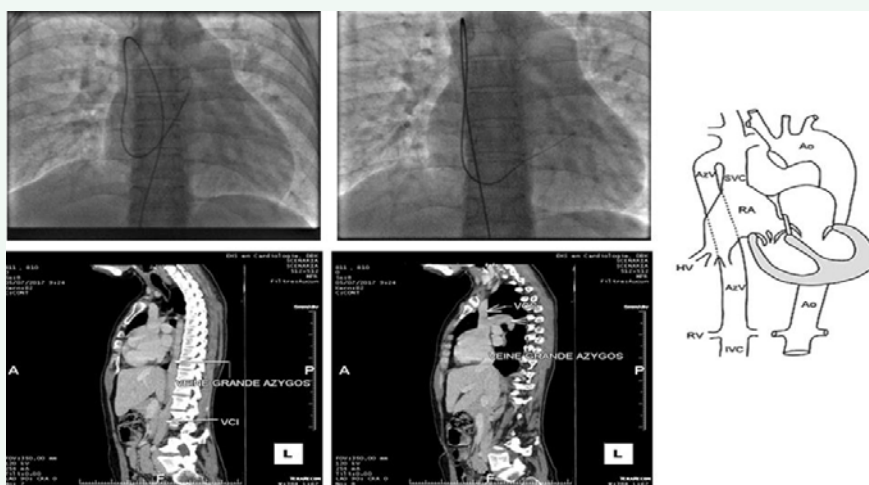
Azygos continuation discovered in angiography and CT.
